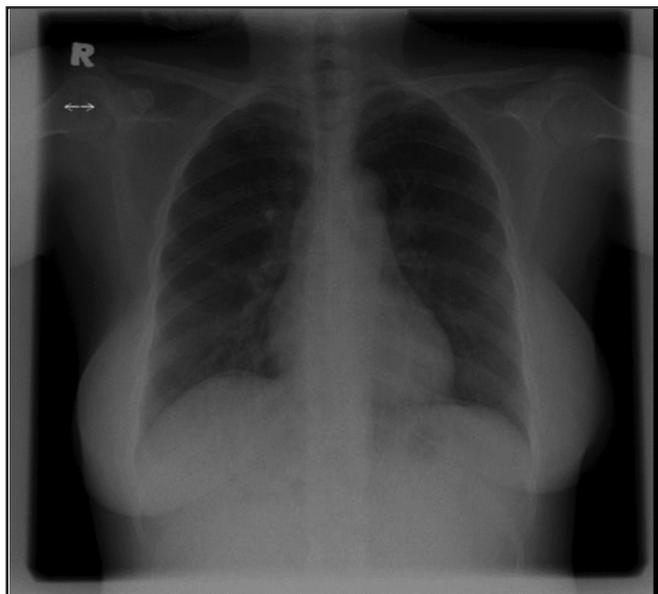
Chest x-ray erect after ERCP which showed bilateral pneumoperitoneum.
